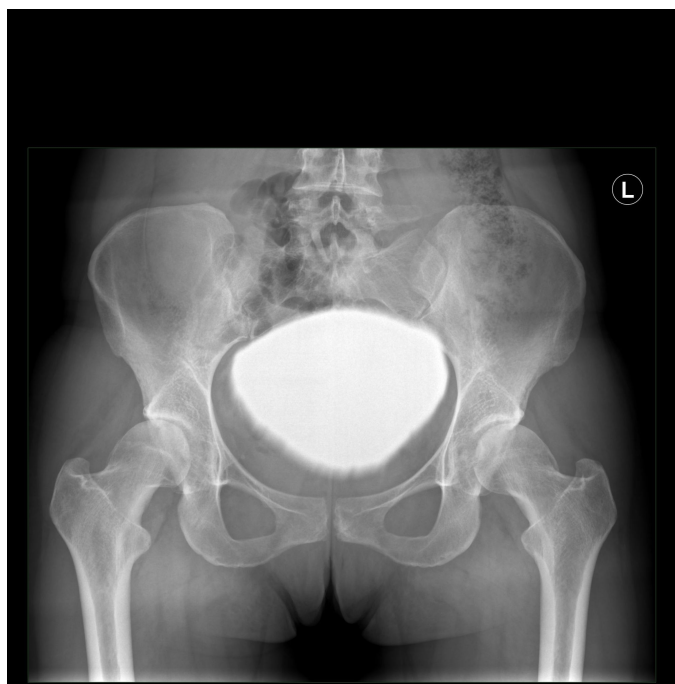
Anteroposterior pelvic radiograph of a patient with acetabular dysplasia and femoral head asphericity (indicative of cam-FAI) with initial joint space narrowing on both sides
